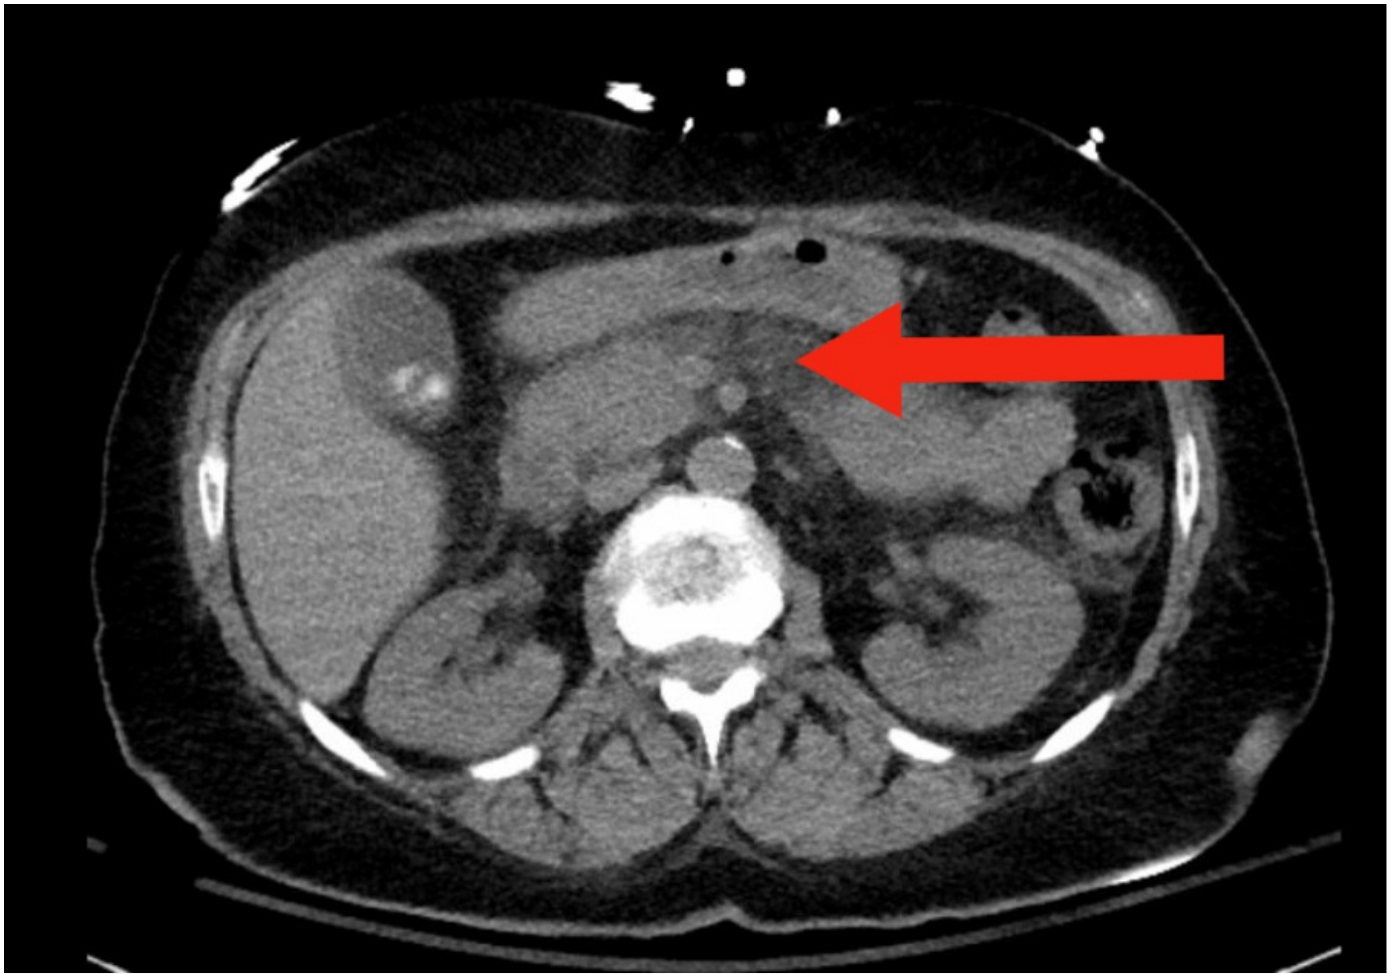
CT Abdomen Pelvis with contrast demonstrating inflammation of the pancreas with peri-pancreatic fat stranding. Also a non-obstructed biliary calculus with biliary sludge.
